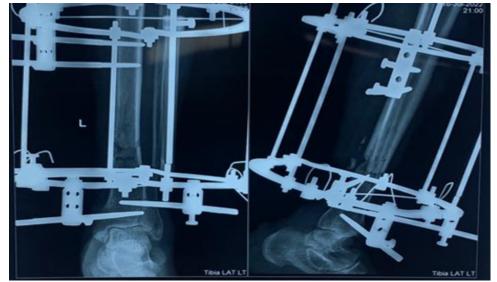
Post operative radiograph with Ilizarov fixator in place.
